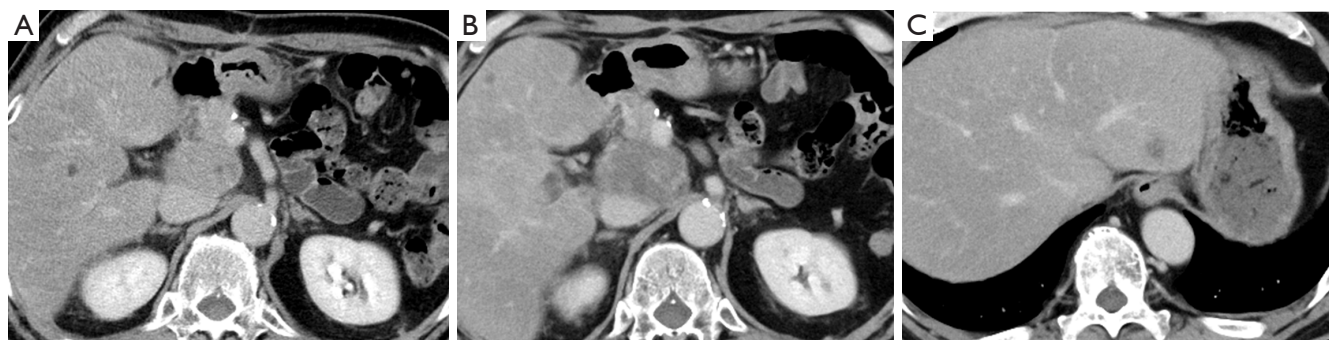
CT imaging after the mFFX therapy. (A,B) After five treatment cycles, the pancreatic (A) and hepatic (B) tumors shrunk to 24 and 32 mm, respectively. (C,D) After 13 treatment cycles, the pancreatic (C) and hepatic (D) tumors shrunk to 10 and 24 mm, respectively. CT, computed tomography; mFFX, modified FORFIRINOX.
